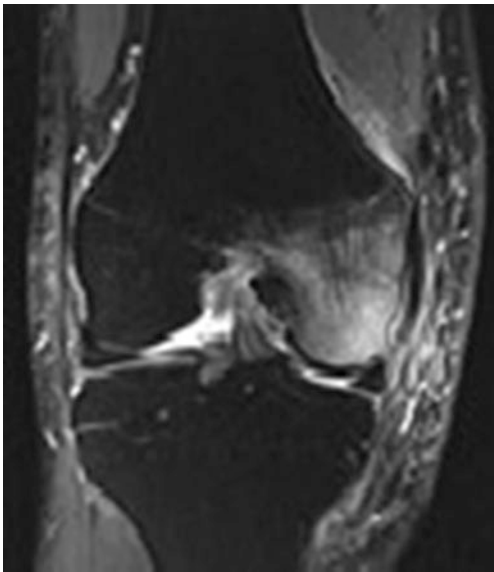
The same patient. MRI view of osteochondral lesion, subchondral fissure, and bone bruise
